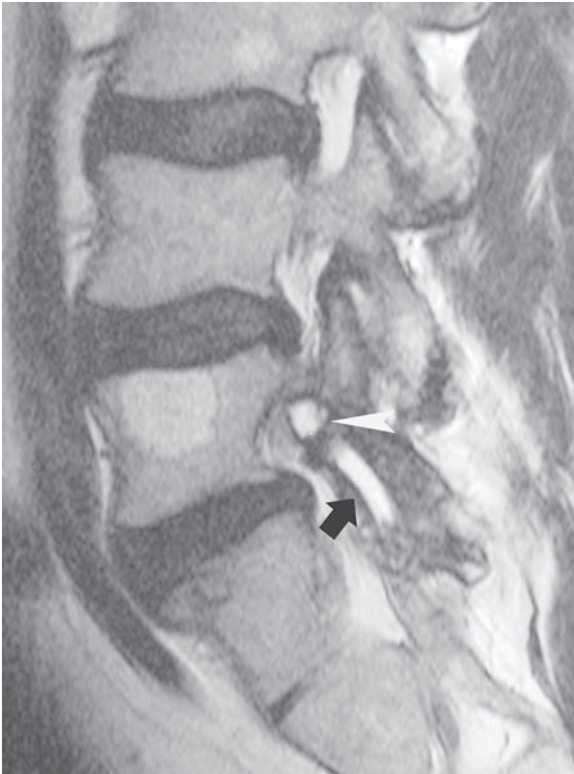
Synovial cyst. Sagittal T2-weighted image demonstrates a synovial cyst (*white arrowhead*) extending into the L5–S1 neural foramen from the adjacent fluid filled (*black arrow*) facet. The cyst abuts the exiting L5 nerve root. Incidentally noted is an L5 vertebral body hemangioma.
